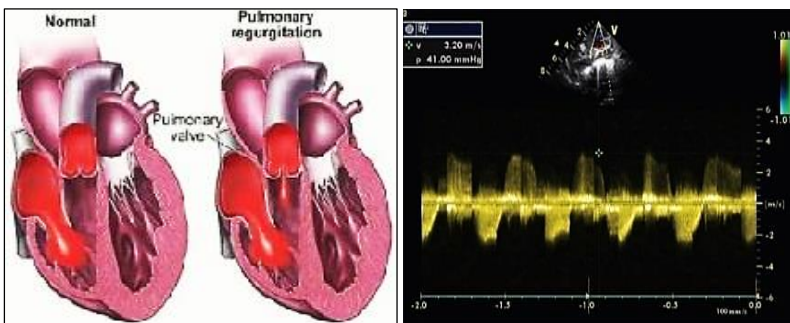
Pulmonary regurgitation & echocardiogram
